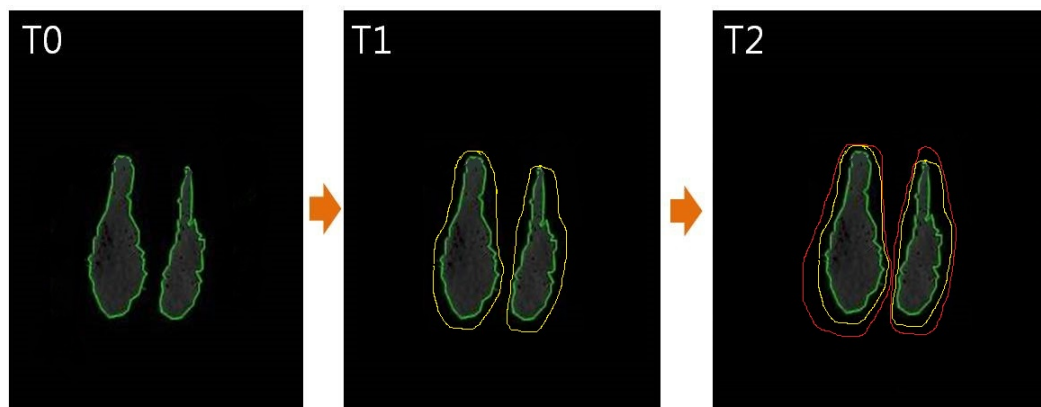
Changes in the anterior cross-sectional area of the airway as measured using cone beam computed tomography before(T0) (green line), immediately after(T1) (yellow line), and 1 year after(T2) (red line) miniscrew-assisted rapid palatal expansion in young adults
